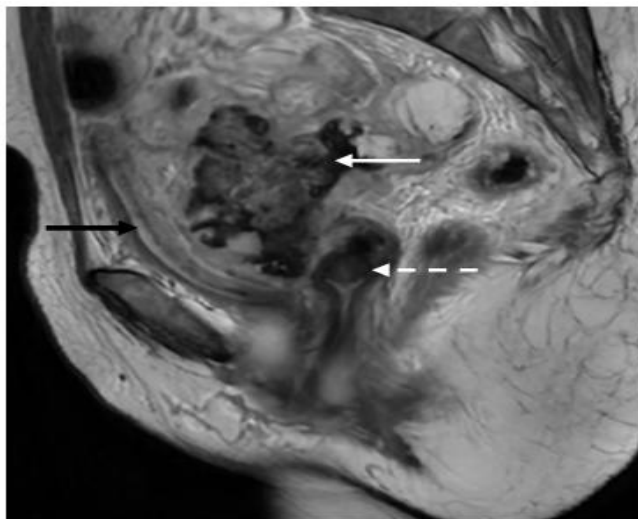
Sagittal T2W MRI image showing T2 hypointensity in the lesion (white solid arrow) lying antero-superior to the vaginal stump (white dashed arrow), and posterior to the bladder (black arrow).
